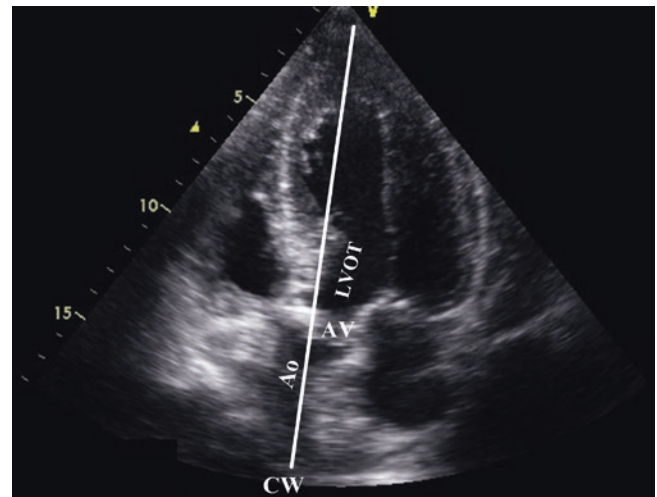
Five-chamber view for evaluation of aortic stenosis. Doppler interrogation of the transaortic velocities is essential in diagnosing aortic stenosis and other causes of left ventricular outflow obstruction. This can be achieved by obtaining a five-chamber view: from the usual four-chamber view the transducer is tilted anteriorly (shallower relative to the chest) to visualize the left ventricular outflow tract (LVOT), aortic valve (AV) and the ascending aorta (Ao). Continuous wave (CW) spectral Doppler can be aligned parallel to the left ventricular outflow using this view to capture the transaortic velocity. While this interrogation can assist in diagnosing aortic stenosis, proper aortic stenosis grading requires multiple interrogations from different insonation angles and should be performed during comprehensive echocardiography. See also Video 20.7
